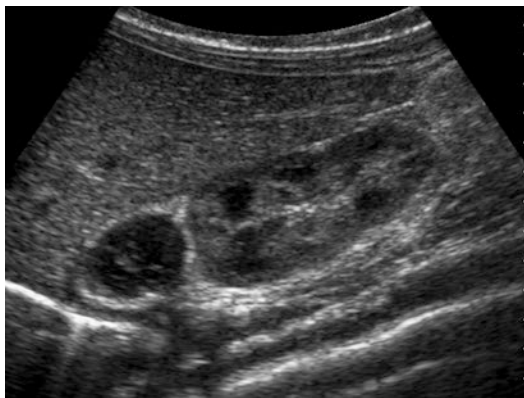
Ultrasound shows a chronic stage adrenal hematoma: the gland is still a little enlarged, its echostructure is predominantly hypo-anechoic, with “pseudocystic aspect”
